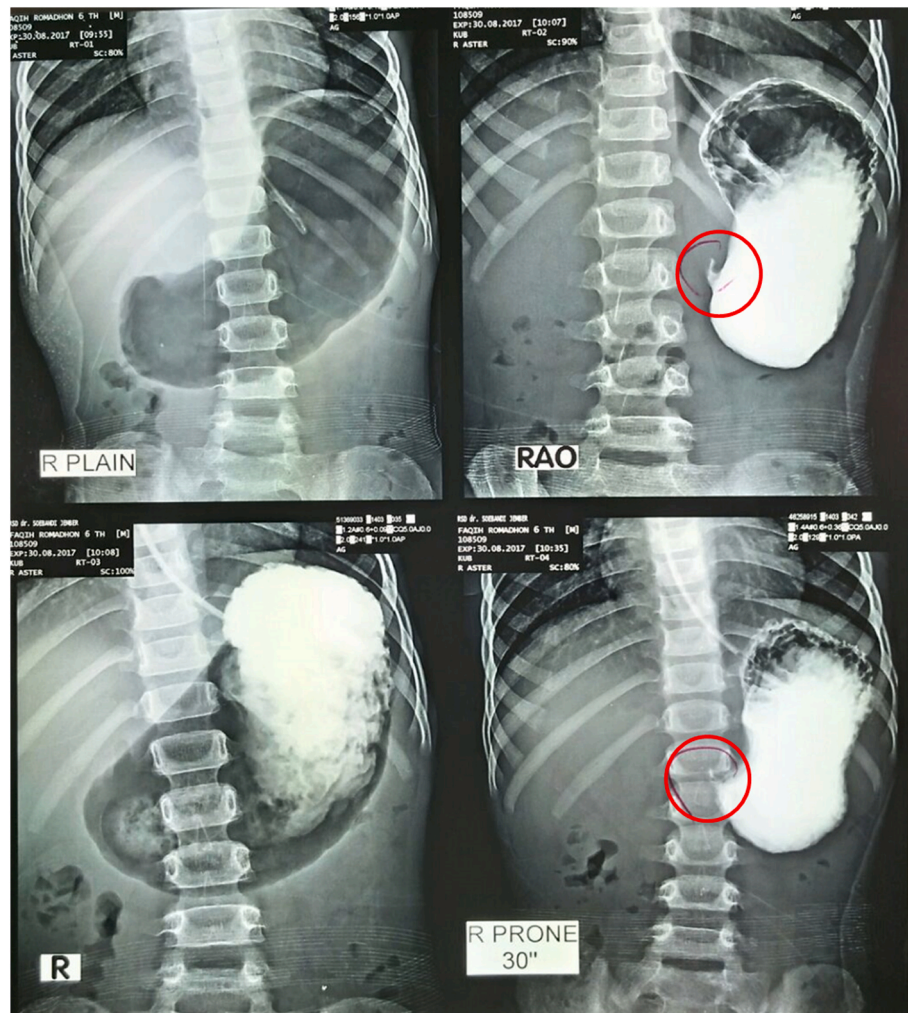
Abdominal radiography examination.
